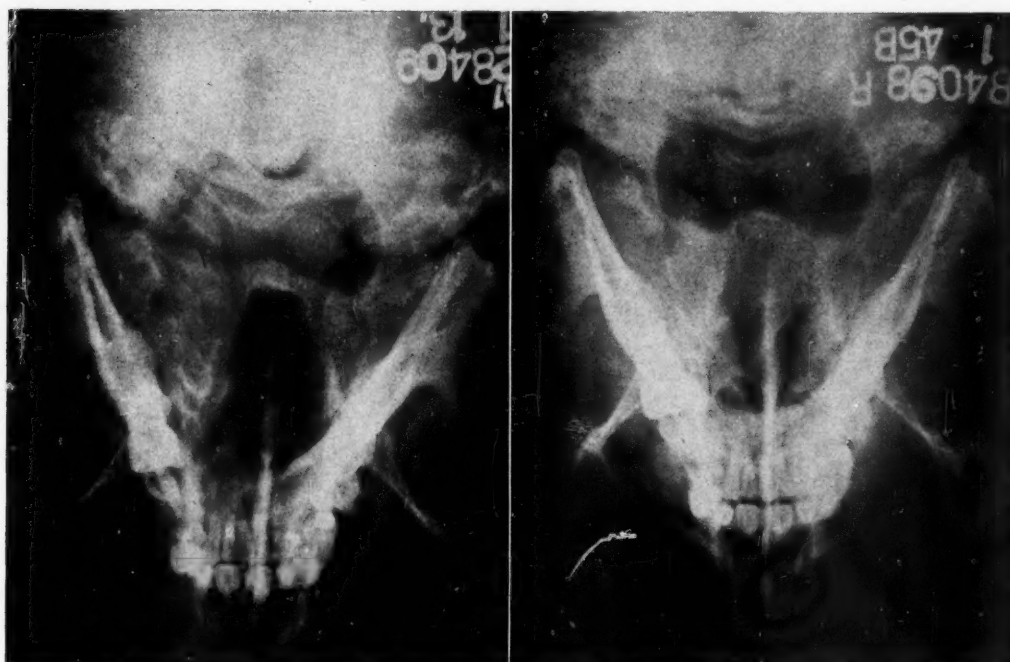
X-rays of sinuses before treatment (left) and eight days after start of treatment (right), revealing complete clearing of the sphenoids.
